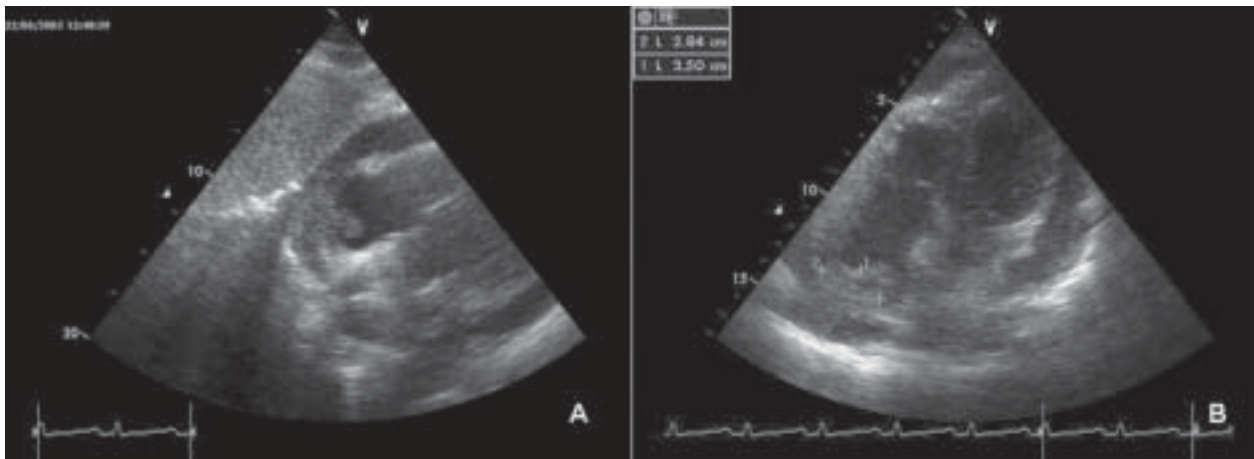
A. Sub-costal view showing a mass inside the pericardium (with pericardial effusion) and extending to the right atrium free wall and inside; B. Apical 4-chamber view showing the pericardial mass extending to the right atrium
